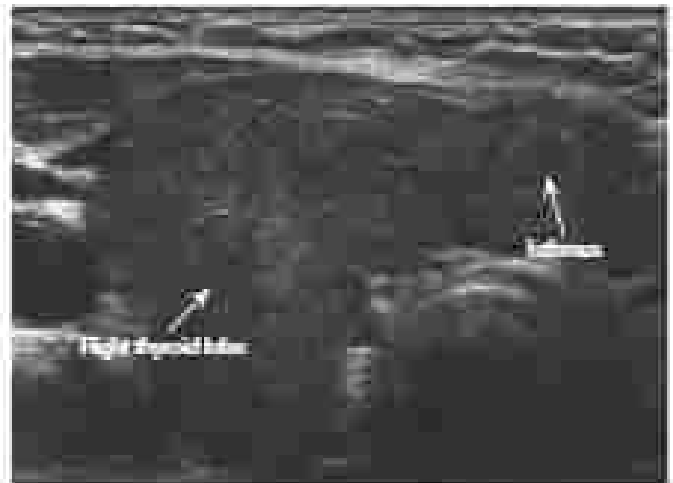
Transverse ultrasound image showing right thyroid lobe and volume in a patient with chronic lymphocytic thyroiditis. The thyroid gland has diffuse and heterogeneous hyperaemia.
